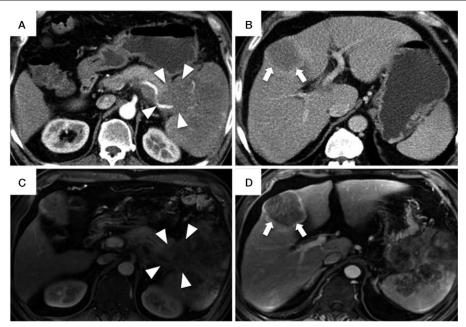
Image studies of the upper abdomen on admission. An abdomen CT (panels A and B) shows a hypovascular mass (arrowhead) located in the tail of pancreas that incased the splenic artery and invaded into the spleen, also shown is a hypovascular left liver mass (arrow), findings suggestive of a pancreatic cancer with liver metastasis. The abdominal MRI (panels C and D) shows similar findings that are suggestive of a pancreatic cancer in the tail of pancreas (arrowhead) with liver metastasis (arrow). CT = computed tomography, MRI = magnetic resonance imaging.
